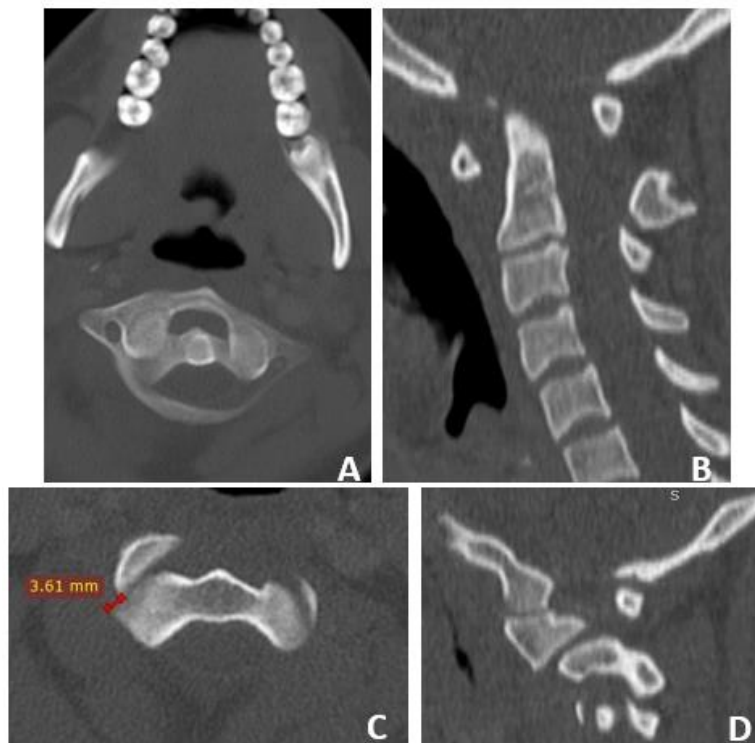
Axial (A, C) and sagittal (B, D) CT images showing a subluxation of the right inferior articular facet of C1 measuring 3.6 mm, consistent with a Fielding and Hawkins type II classification
